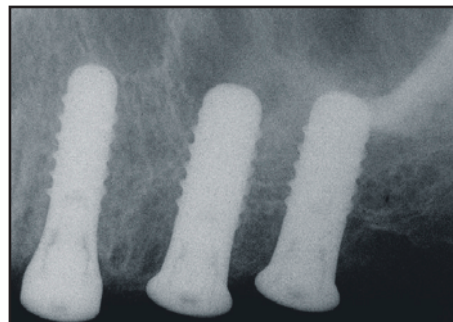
Immediate postoperative radiograph of implants at sites #12 through #14.
